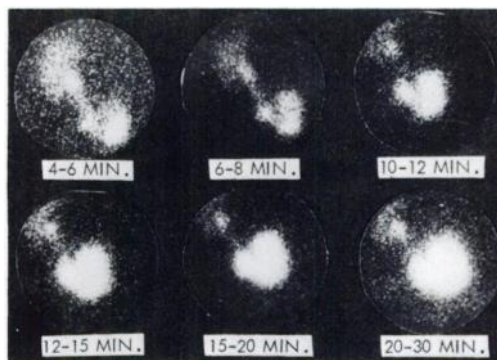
Renal transplant scintigraphic study of kidney, ureter, and bladder visualized with Hippuran shows persistent collection over distal ureter.
